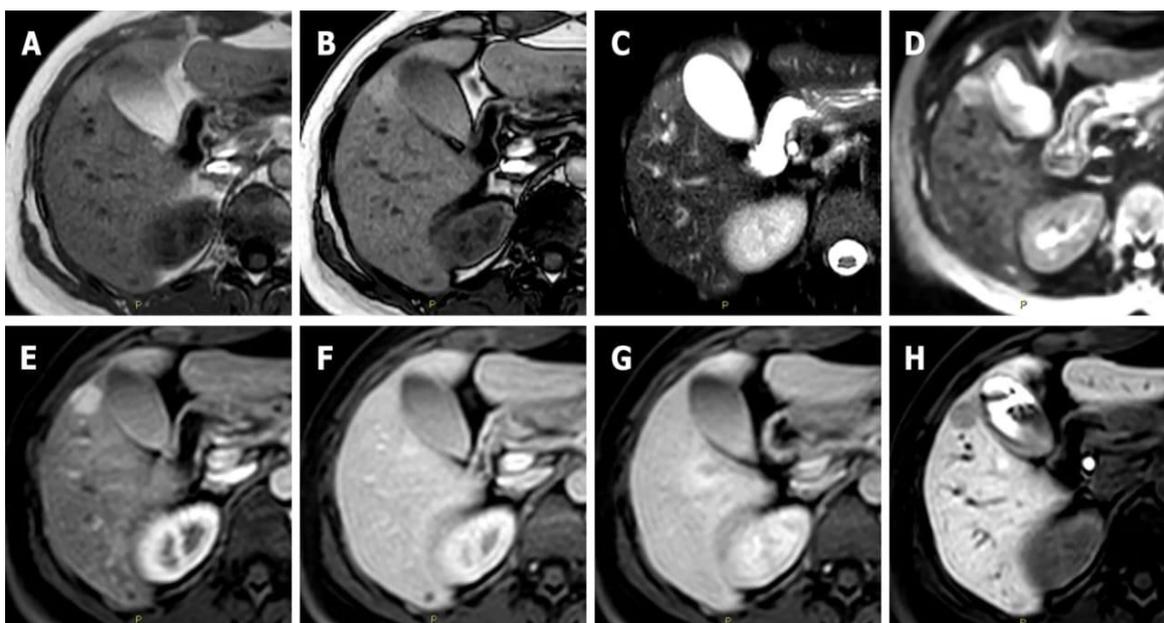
A: In a 47-year-old woman the axial T1 in-phase; B: Out-of-phase images show an isointense lesion in liver segment V; C: Hyperintense in the T2-weighted; D: In the diffusion-weighted; E: In the arterial phase images; F: Without washout of the contrast media in the portal-venous phase; G: In the delayed phase images; H: Hypointense in the hepatobiliary phase image. [Fig-11]
